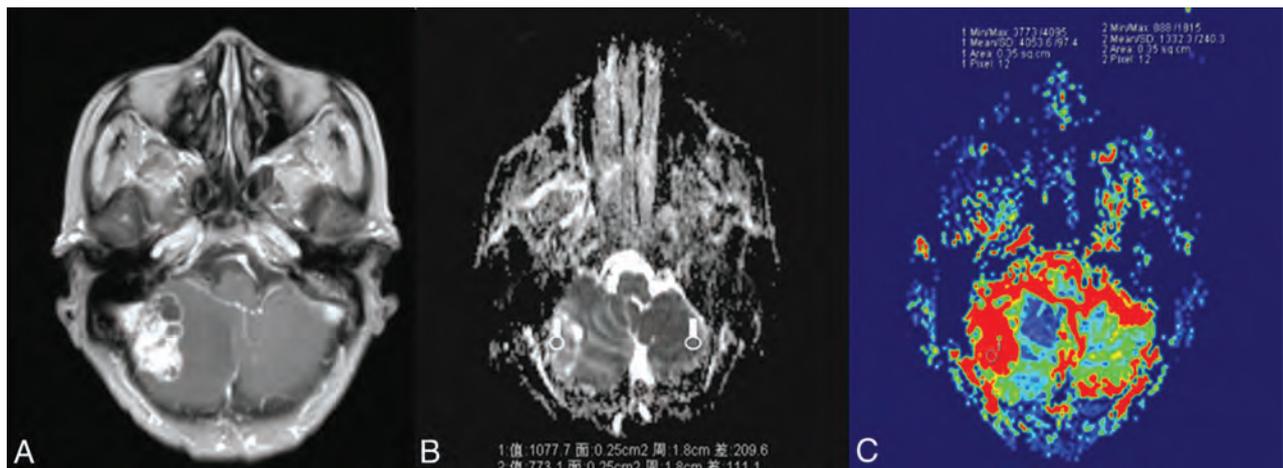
A 70-year-old man with a single brain metastasis. *A*, Contrast-enhanced axial T1-weighted image demonstrates a contrast-enhancing lesion on the right cerebellar hemisphere. *B*, A corresponding ADC map shows the tumor to have a slightly increased ADC value ($ADC_{min} = 1077.7 \times 10^{-3} \text{ mm}^2/\text{s}$, $rADC = 1.39$). *C*, A correlative color CBV image shows moderately elevated perfusion with the calculated $rCBV_{max}$ of 3.04.
